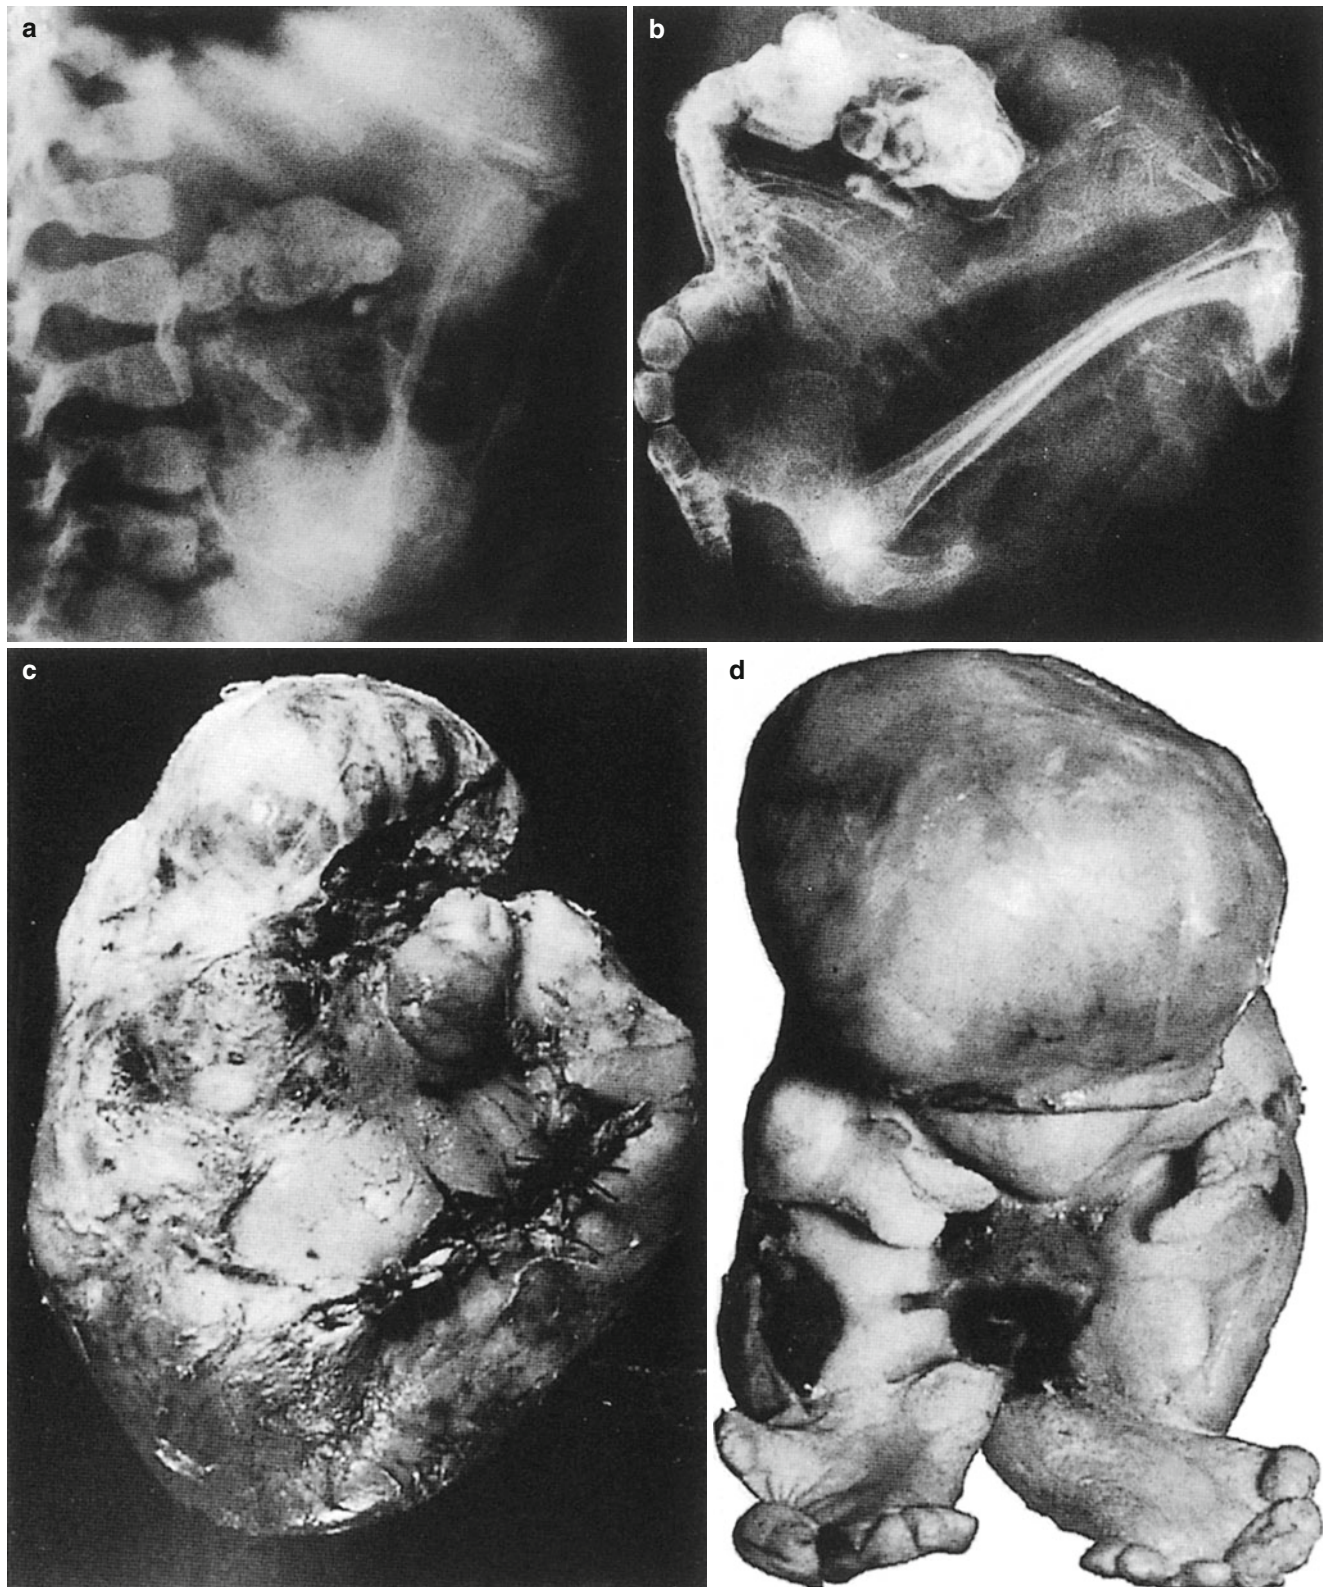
Fetus-in-fetu. Radiographs of a retroperitoneal mass resembling a fetus in a 1-year-old child. (a) Before removal from the abdomen. (b) After removal. (c) External surface of the mass shown in (a). (c) Before removal of the outer covering. (d) After removal of outer covering. (e) Sagittal section shows well-developed vertebra, spinal nerves, base of skull, and cystic replacement of the brain. The large
